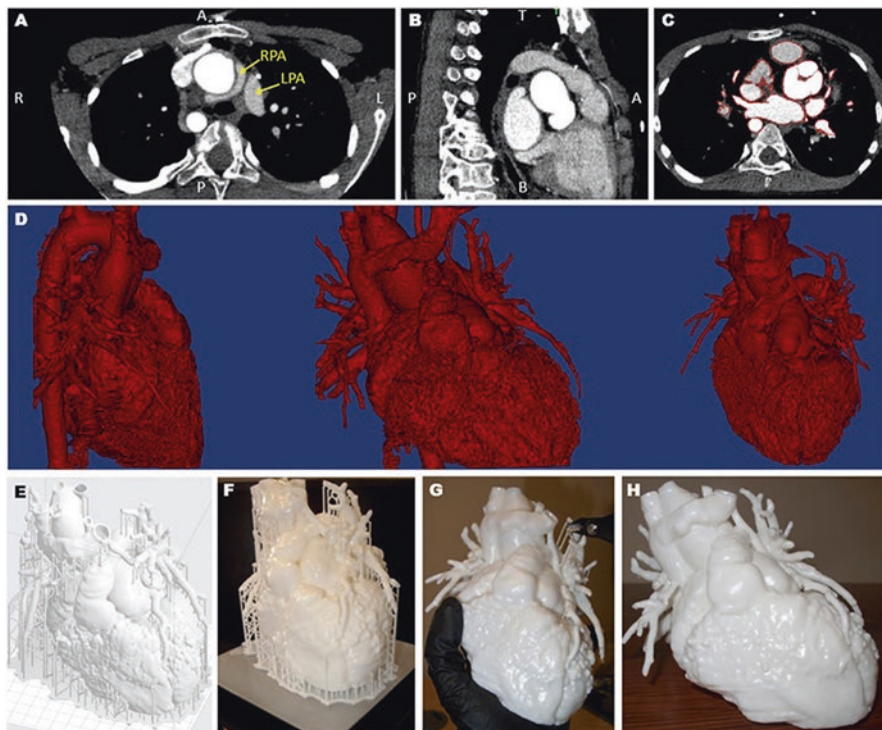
Patient-specific model of heart segmented from computed tomography scans (a–c) into a 3D model (d). Sacrificial support scaffolds are generated (e), printed (f), and removed (g) to generate the finished heart model (h) [16]
